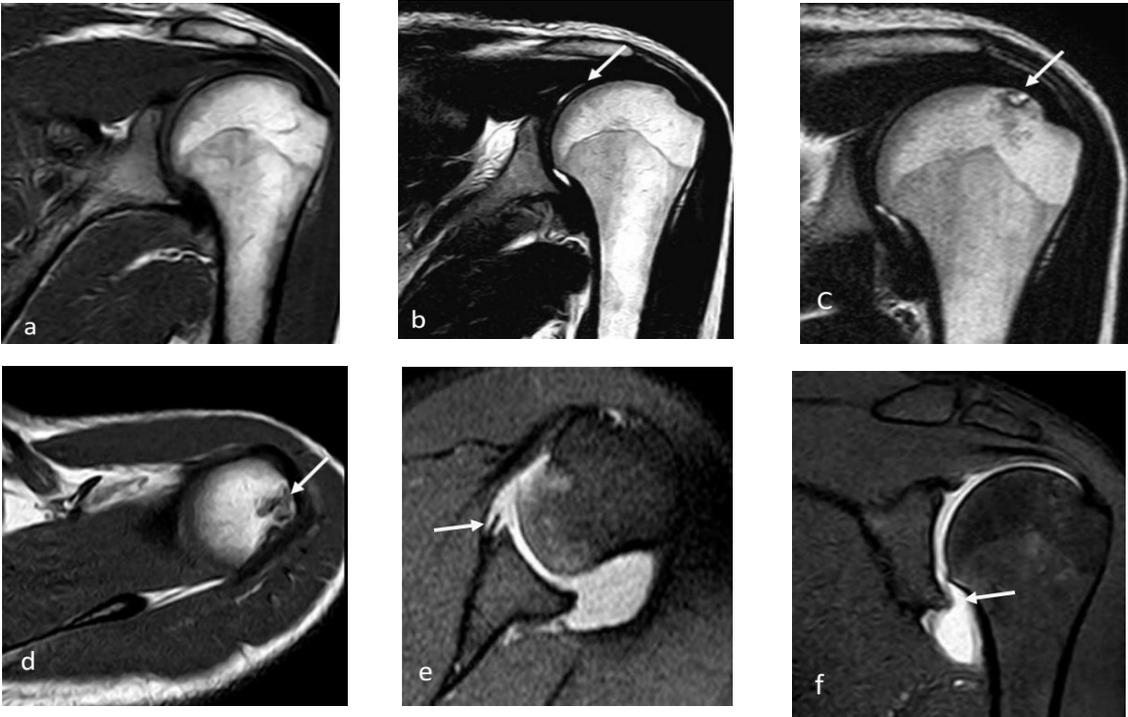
Conventional MRI: Coronal T1 (a) coronal T2 (b,c) and axial T1 (d) showing minimal joint effusion and abnormal low T1 and high T2 signal in the posterolateral aspect of the humeral head (arrows). MR Arthrography: Axial T1 Fat Sat (e) and coronal T1 Fat Sat (f) showed avulsion of the anterior inferior labrum glenoidal, with contrast filling under the scapular periosteum (arrows).
